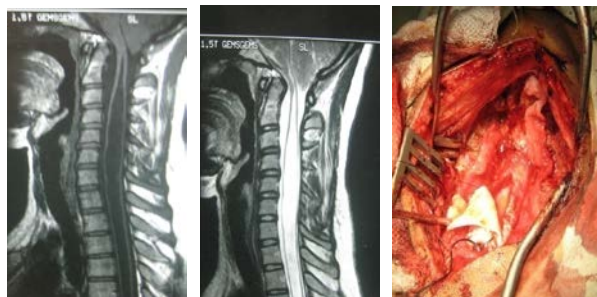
MRI of case 3, Syrinx Fig: Duroplasty is going reached down to mid dorsal on region
